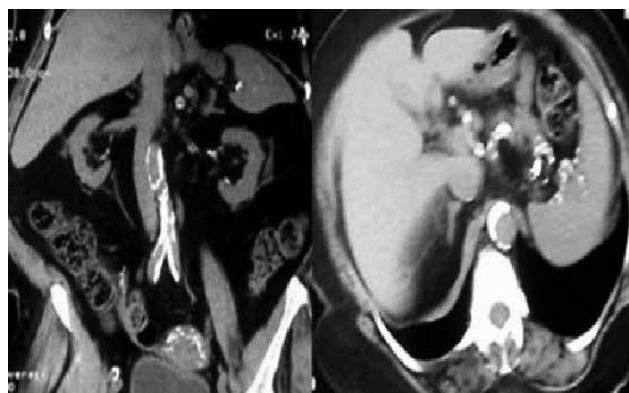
Multislice computed tomography image of abdominal aorta showing multiple calcification sites.
